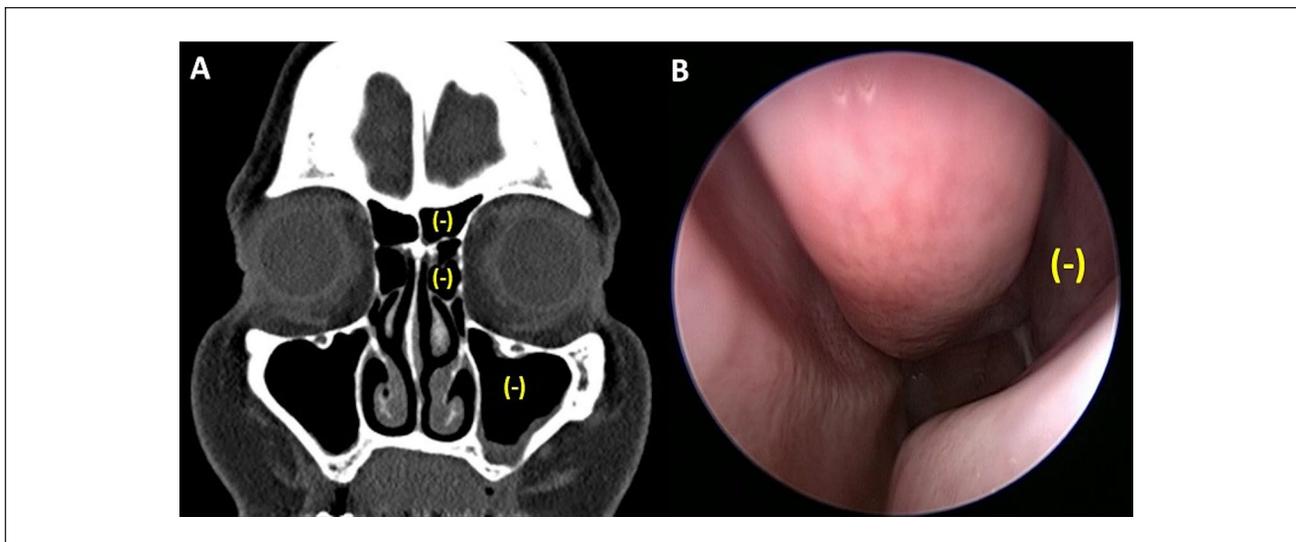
Example of how concurrence of negative findings was assessed between (A) left maxillary, anterior ethmoid, and frontal sinuses on computed tomography, and (B) left-sided middle meatal endoscopy. (-) Connotes grades of “negative” for the given diagnostic modality.
